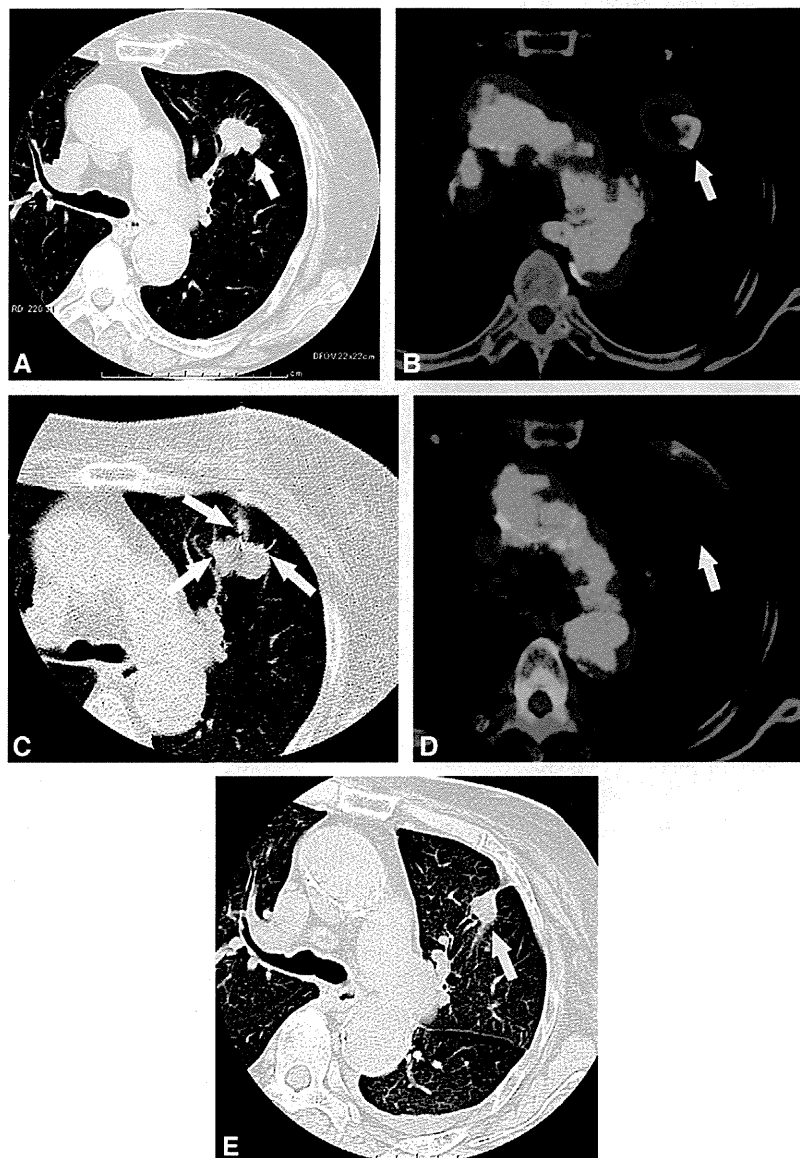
RFA for a 79-year-old woman with clinical stage IA NSCLC. A, CT image before the procedure shows a tumor (*arrow*) of 29 mm in maximum diameter in the left upper lobe. B, PET/CT image before the procedure shows marked accumulation of ^{18}F -fluorodeoxy glucose into the tumor (*arrow*). C, CT-fluoroscopic image during the procedure shows that a multitined expandable electrode (*arrows*) is introduced into the tumor. D, PET/CT image 3 months after the procedure shows no obvious accumulation of ^{18}F -fluorodeoxy glucose into the tumor (*arrow*). E, CT image 31 months after the procedure shows considerable tumor involution (*arrow*).
